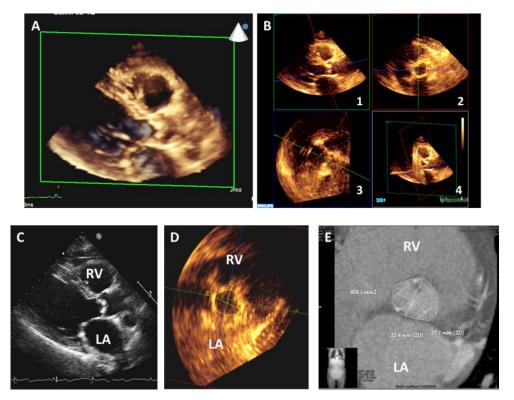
AoA measured by 2DTTE, 3DTTE and MDCT. Example of 3D TTE from the parasternal long axis view (A) and of AoA measurement. B. The 3D dataset was analyzed through 3 different orthogonal cut planes: red plane (1) is a short-axis view of aortic root crossing AoA; green (2) and blue (3) planes are sagittal views of the ascending aorta. The red plane was shifted from aortic root towards left ventricular outflow tract until aortic valve cusps disappeared, allowing the measurement of the AoA. (4) The position and the relationship of each plane in the 3D dataset are shown. C. AoA diameter measured by 2DTTE in a parasternal long axis view. AoA minimum diameter, maximum diameter and area measured in a cross-sectional plane of a 3DTTE (D) and multidetector computed tomography (MDCT, E) dataset. RV = right ventricle, LA = left atrium.
